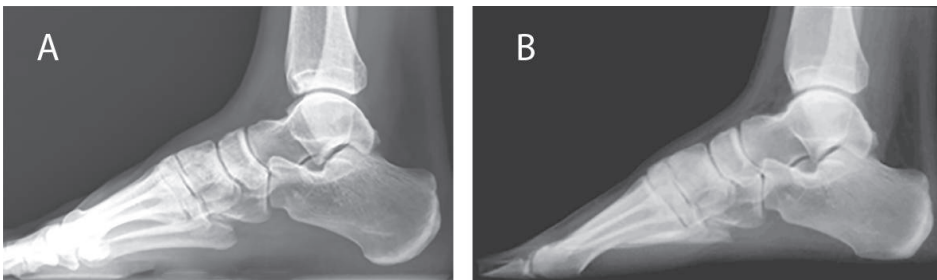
A. Conventional radiographic image, Standard Lateral View. B. Digitally Reconstructed Radiograph (DRR) of the same ankle.
